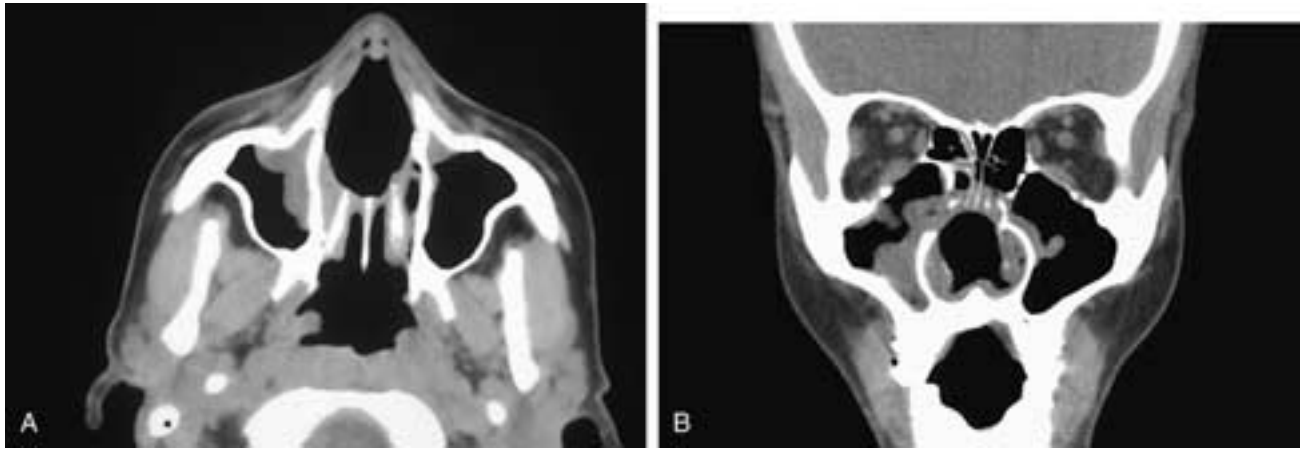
Axial (A) and coronal (B) CT scans show destruction of the nasal septum and portions of each medial maxillary sinus wall and the lower ethmoid complex. The distribution of disease suggests a granulomatous process. This patient was a chronic cocaine abuser.
